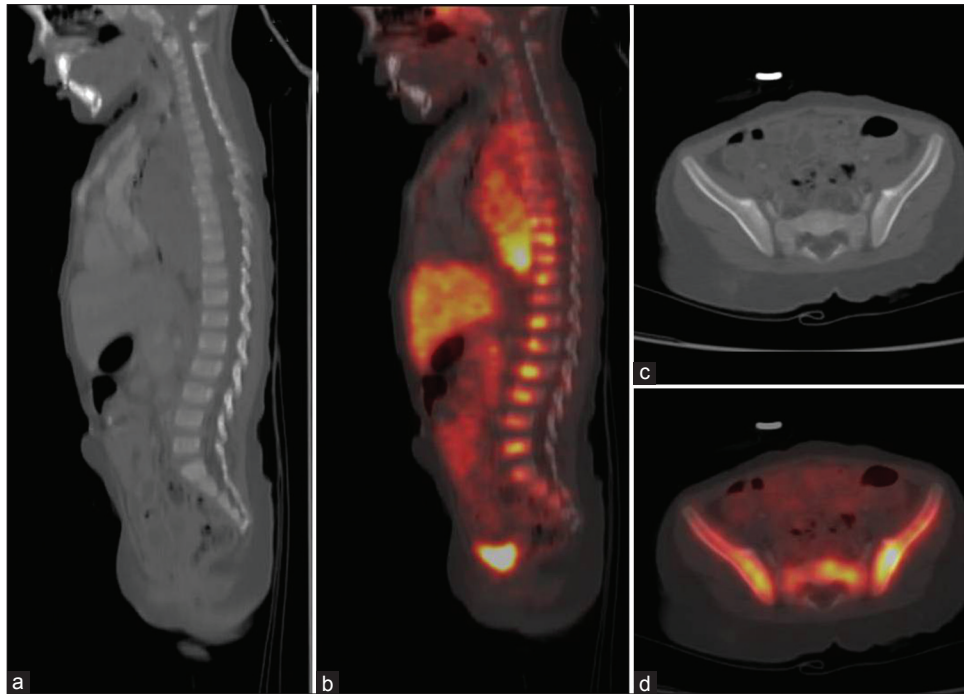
A 4-year-old female child with suspected neuroblastoma showed multiple intensely ⁶⁸Ga-DOTATATE avid foci in dorso-lumbar vertebrae (b) Pelvis (d) With no definite changes on computed tomography (a and c) Upstaging the disease to stage IV
